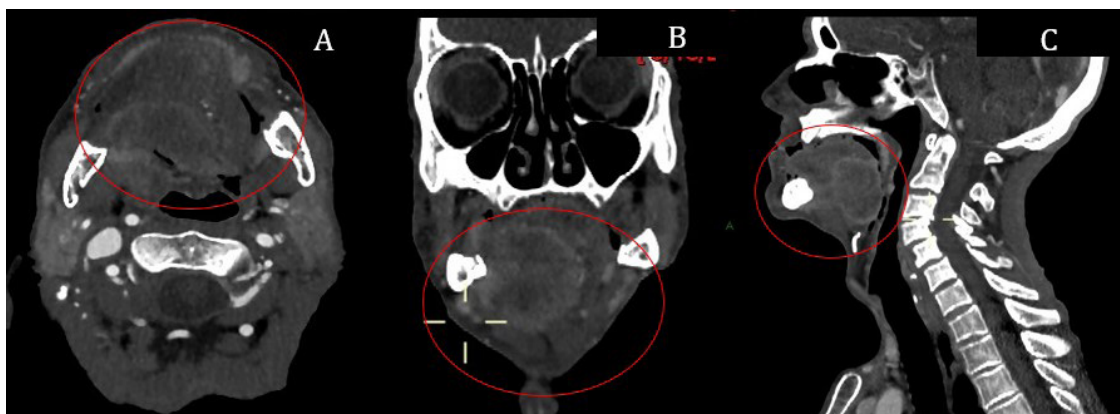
Multidetector computed tomography sections in different cross-sectional planes: transverse (A), coronal (B), and sagittal (C), with the indication of iodophilic mass
